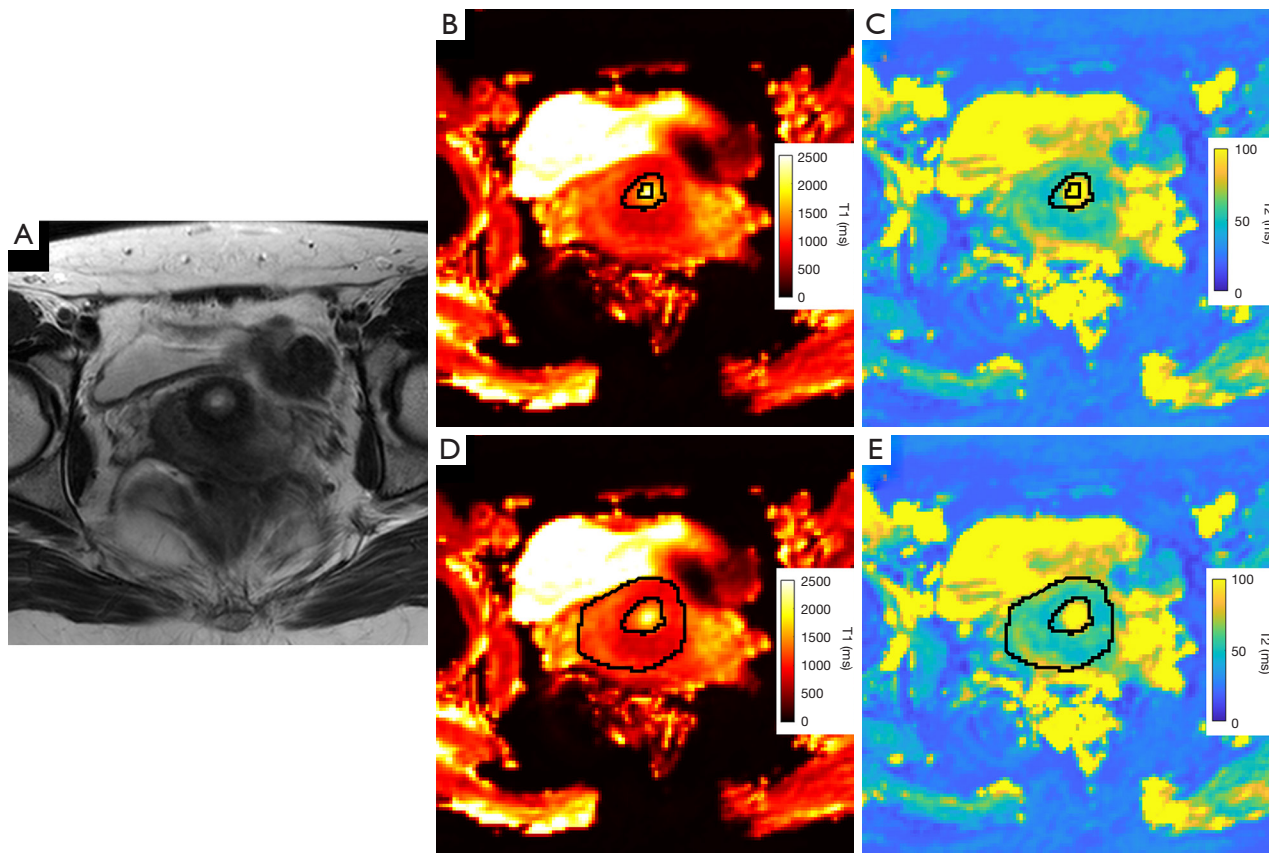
A 26-year-old female healthy volunteer. (A) Axial T2-weighted image, (B,D) T1 maps and (C,E) T2 maps. Representative VOIs of mucosa (B,C) and stroma (D,E) were shown on the T1 and T2 maps. The VOIs appear as a pair of black rings, and the included area were the pixels between the inner and outer rings; the area within the inner ring was excluded. VOI, volume of interest.
